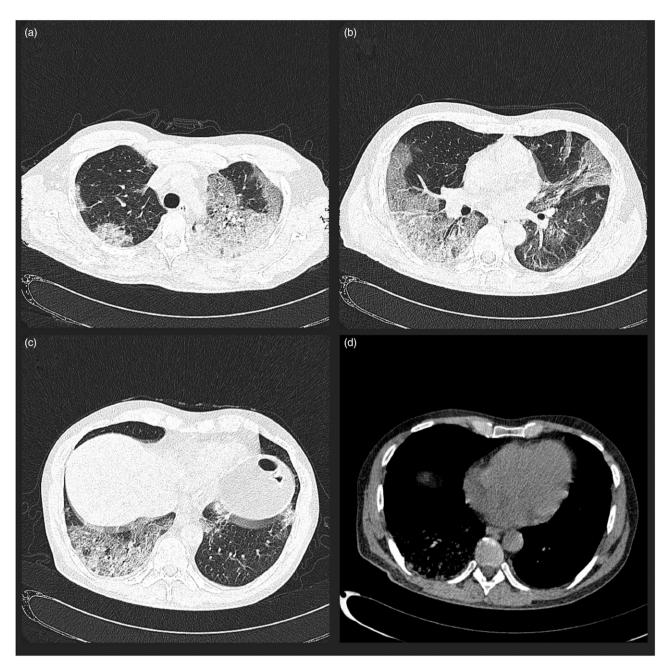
Images a, b, and c represent the lung window (W:1600 HU, L: -500 HU) of the baseline chest CT describing the multilobar COVID-19 pneumonia with a crazy paving pattern and with a peripheral and central distribution, with a CT-SS of 16/25. The left superior lobe and the right inferior lobe were more involved than the others. In the image, d represents the mediastinal window (W: 251 HU, L: 45HU). No pleural effusion was seen on the left side.
